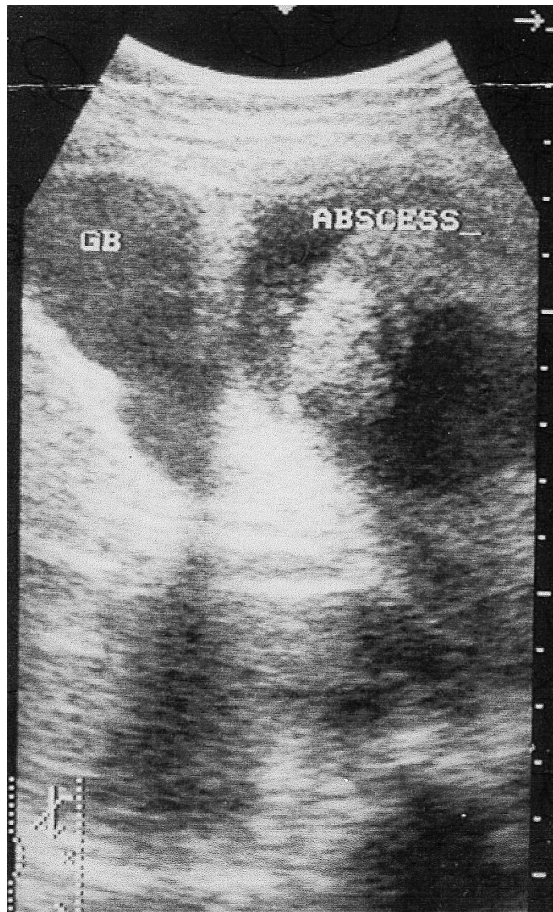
Ultrasonography showed wall thickening of the gallbladder and abscess formation adjacent to the gallbladder.
